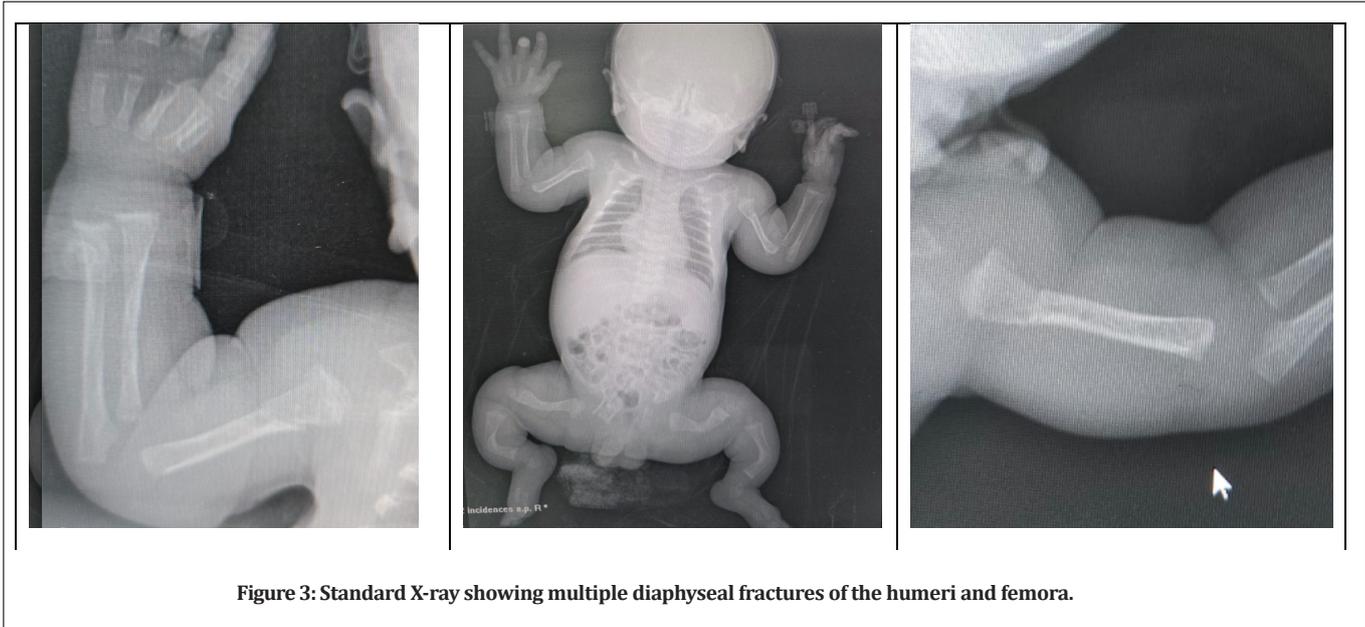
Standard X-ray showing multiple diaphyseal fractures of the humeri and femora.
